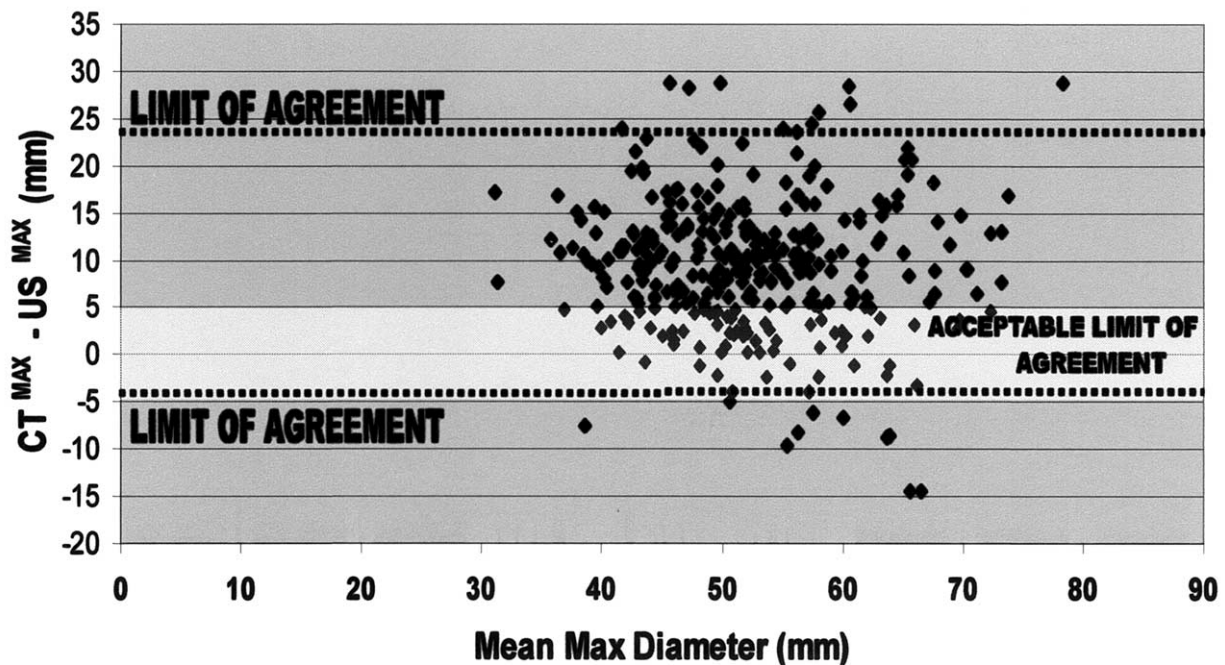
Limits of agreement (broken lines) between CT^{max} and US^{max} (-4.5 - 23.6 mm) compared with clinically acceptable limits of agreement (highlighted area) between CT^{max} and US^{max} (-5.0 - 5.0 mm).
